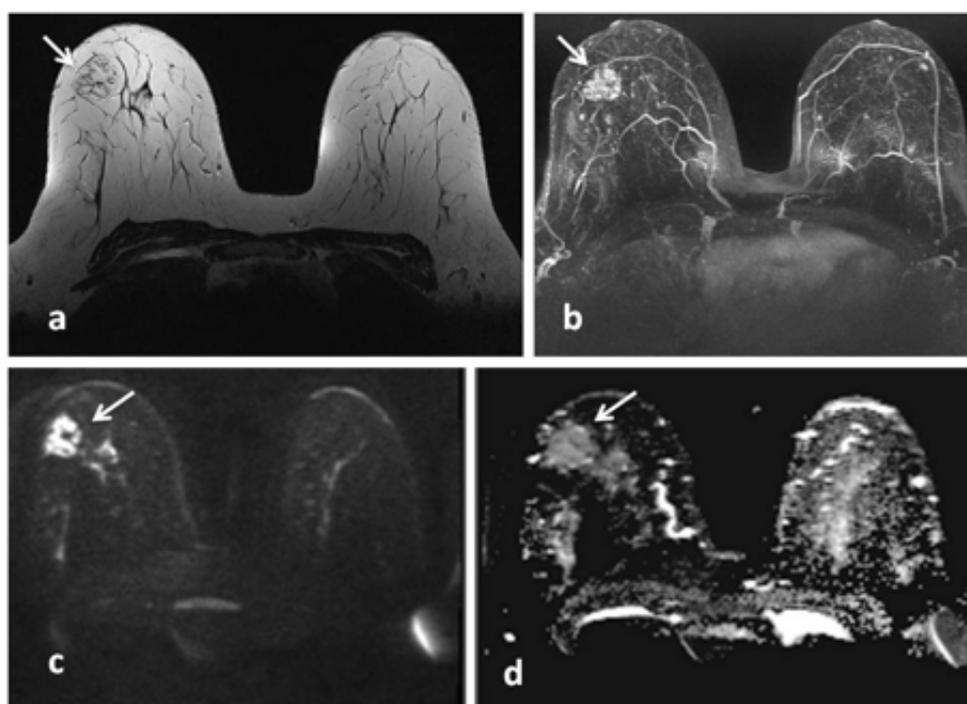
Axial T2 weighted image demonstrates an encapsulated mass (a), MIP image have revealed a mass with type 1 contrast enhancement pattern (b), DWI (c), and ADC mapping (d) demonstrates diffusion restriction of mass (arrow). MIP = maximum intensity projection, DWI = diffusion weighted imaging, ADC = apparent diffusion coefficient.
